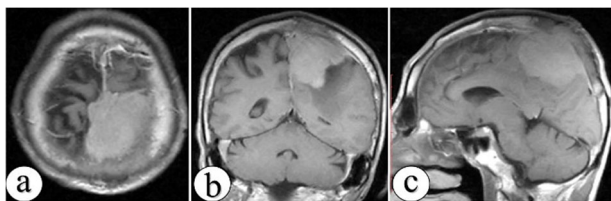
Meningiomas with dural sinus invasion increase the risk of dissemination: atypical meningioma (WHO grade II meningioma) with invasion of the superior sagittal sinus; male, 58-year-old, head MRI (TIWI + contrast), with axial (a), coronal (b) and sagittal (c) section. MRI: Magnetic resonance imaging; TIWI: T1 weighted image; WHO: World Health Organization.
